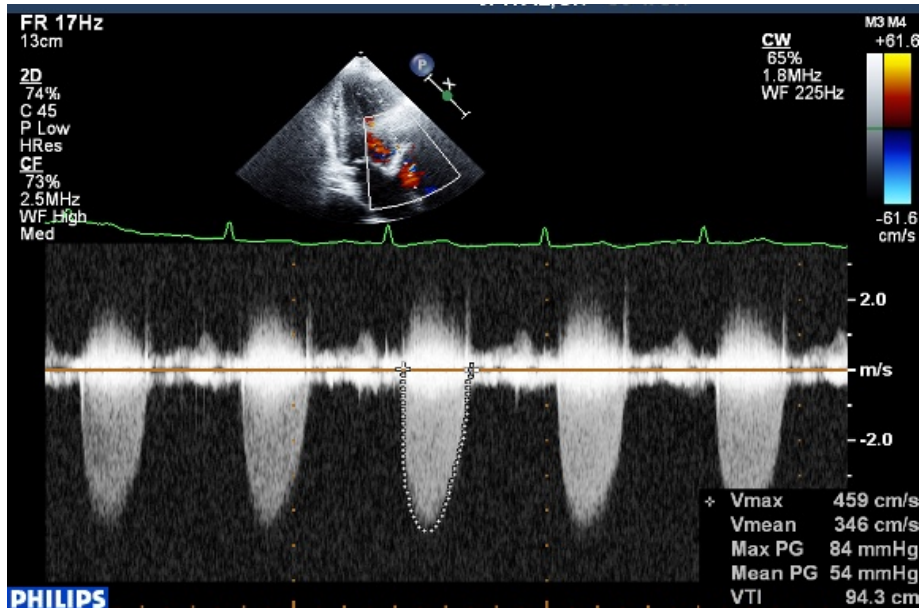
Continuous wave doppler across the aortic valve showing peak velocity of 4.59 m/s and mean gradient of 54 mmHg, suggestive of severe AS.
